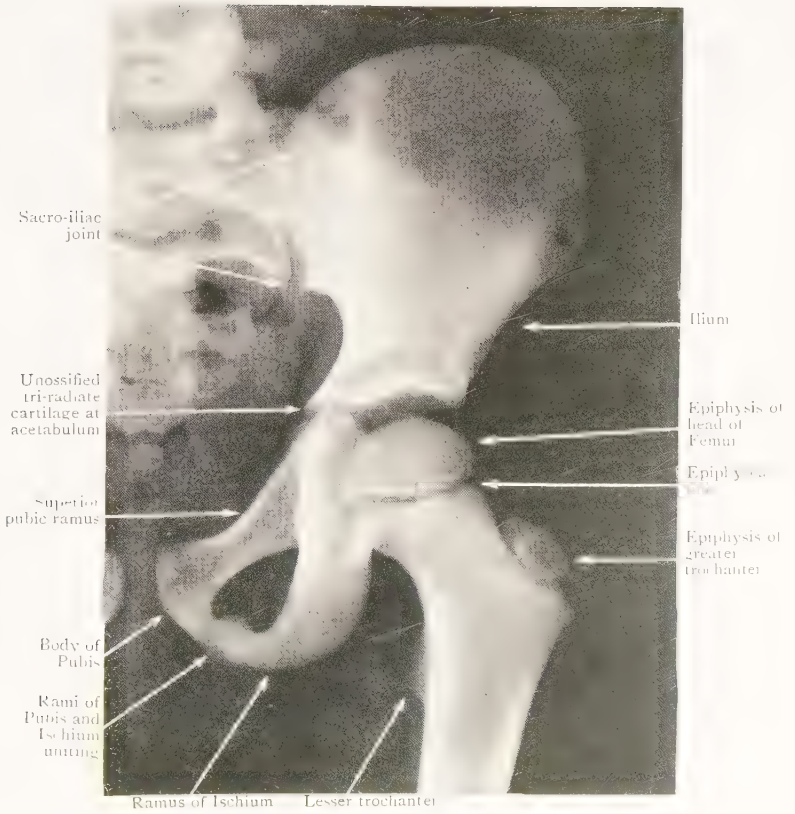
Radiograph of Hip of boy aged 7.
